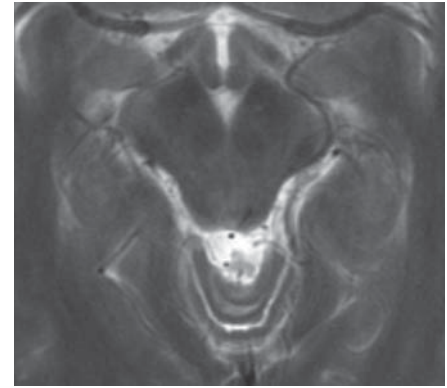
MRI of the brain on 11.02.2005, T2 TSE axial (TR 4980, TE 104). Seventeen days later, only discrete T2 signal hyperintensity in the left inferior colliculus with slight central signal reduction.
